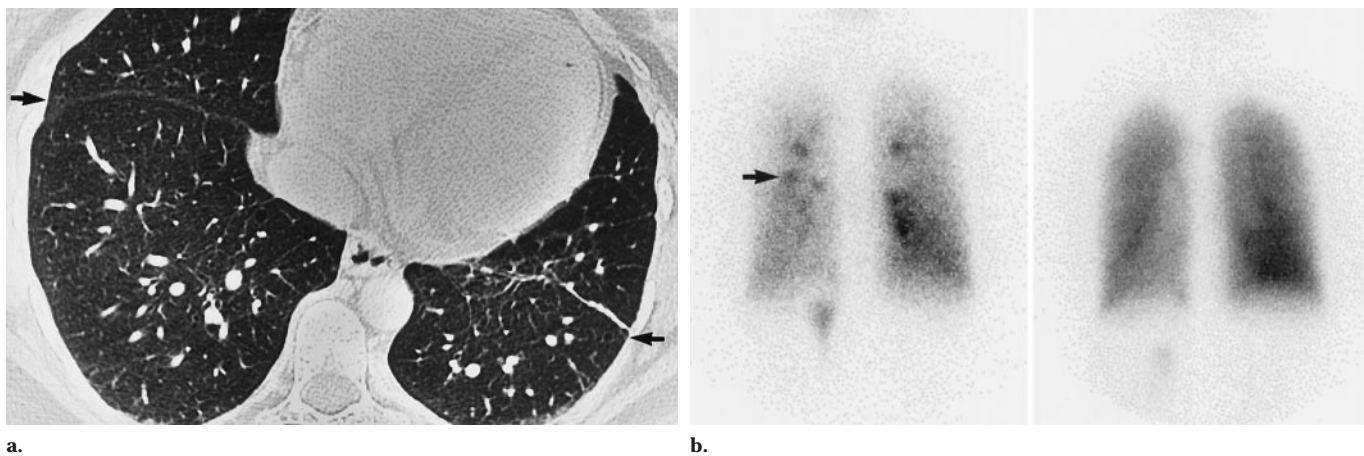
Lymphangioleiomyomatosis in a 35-year-old woman. (a) Transverse thin-section CT scan and (b) posterior ventilation (left) and perfusion (right) images demonstrate minimal extent of disease visible on the CT scan, which consists of pulmonary cysts (arrows in a) involving less than 30% of the lungs, normal ventilation, minimally abnormal perfusion, and minimal speckling (arrow in b).
